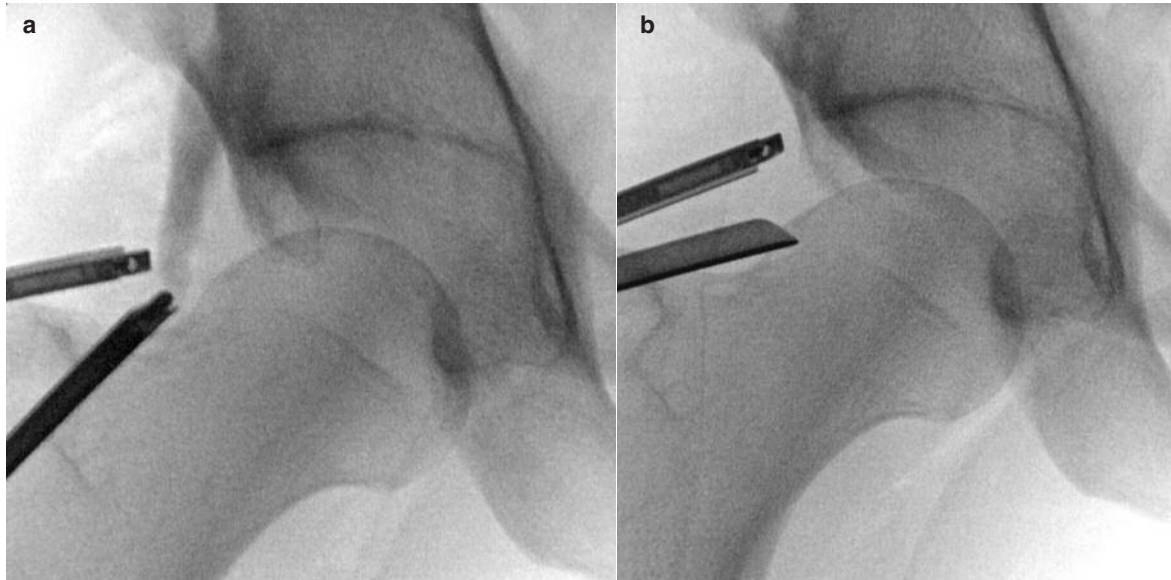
a, b. a) Localisation of AIIS exostosis under intra-operative X-ray; b) Resection of exostosis.
